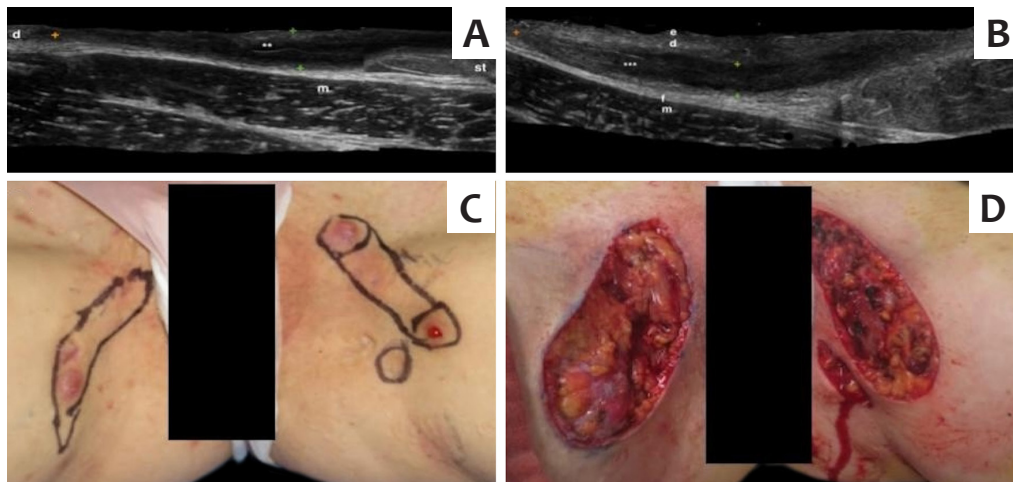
A - High-resolution ultrasound with 18-24 MHz linear golf club transducer of the inner third of the right thigh showing a tubular, elongated structure with well-defined borders corresponding to a Type II fistula with fibrosis in the wall. Asterisks () indicate a retained monofilament hair tract in the fistula. Green calipers (+) delineate the fistula thickness, which extends to the muscle fascia (m), and orange calipers indicate the fistula length. B - High-resolution ultrasound with 18-24 MHz linear golf club transducer of the inner third of the left thigh showing a tubular, elongated structure with well-defined borders corresponding to a Type III fistula with fibrosis in the wall and edema in the periphery. Asterisks () indicate a retained monofilament hair tract in the fistula. Green calipers (+) delineate the fistula thickness, which extends to the fascia (f) of the muscle (m), and orange calipers indicate the fistula length. C - Fistula and nodule marking. D - Surgical resection guided by prior ultrasound marking.
